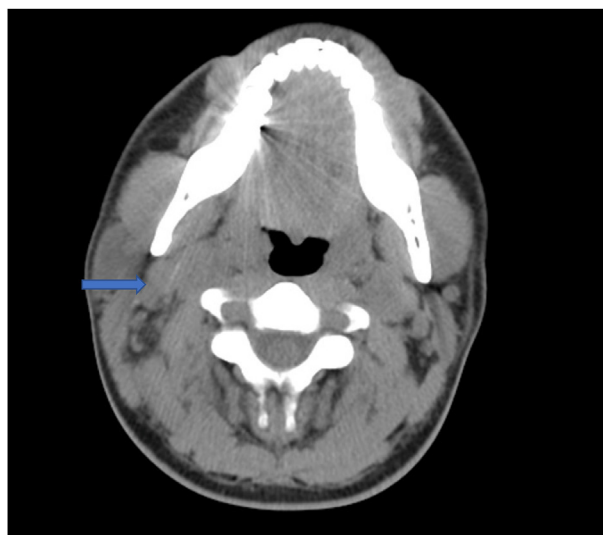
Level II cervical lymphadenopathy in CT soft tissue neck.
